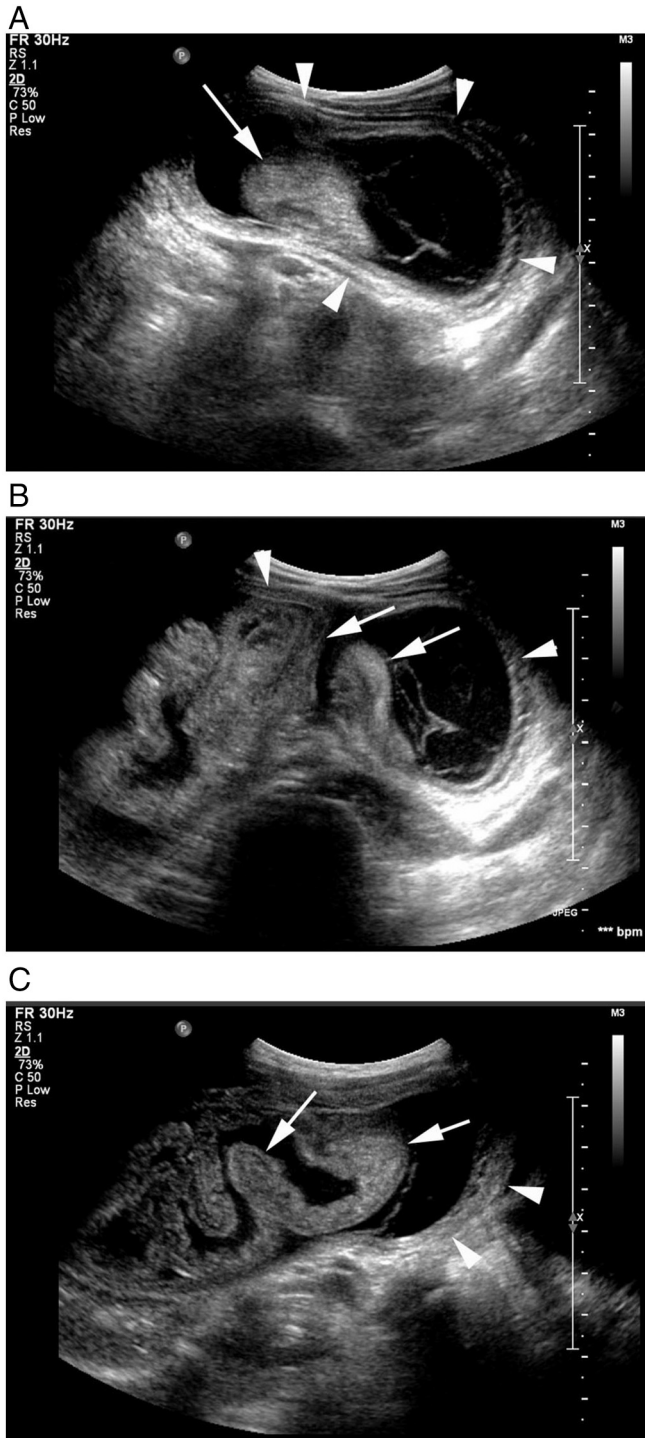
Transverse (A and B) and longitudinal (C) grayscale ultrasound images of the left lower quadrant demonstrating multiple decompressed small bowel loops (arrows) with anechoic adjacent fluid containing echogenic septations, encased in a thick-walled structure (arrowheads) extending across the abdominal cavity.
